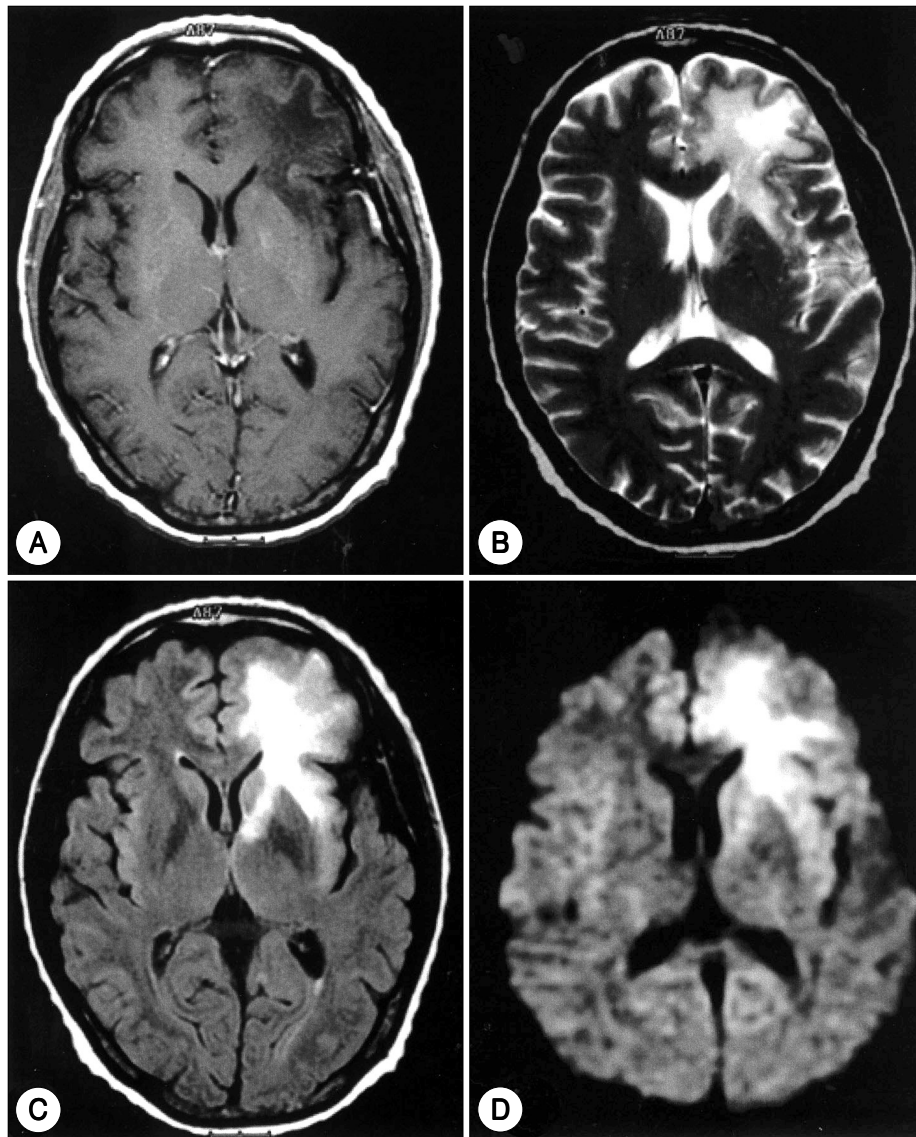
Follow-up brain MRI(8 days before brain biopsy) showing non-enhanced, hypointense, diffuse lesion involving white matter of left frontal lobe, insula, and anterior limb and genu of internal capsule in T1WI (A). In T2WI (B), FLAIR (C), and DWI (D), the lesion is hyperintense without mass effect and the gray matter is spared.
